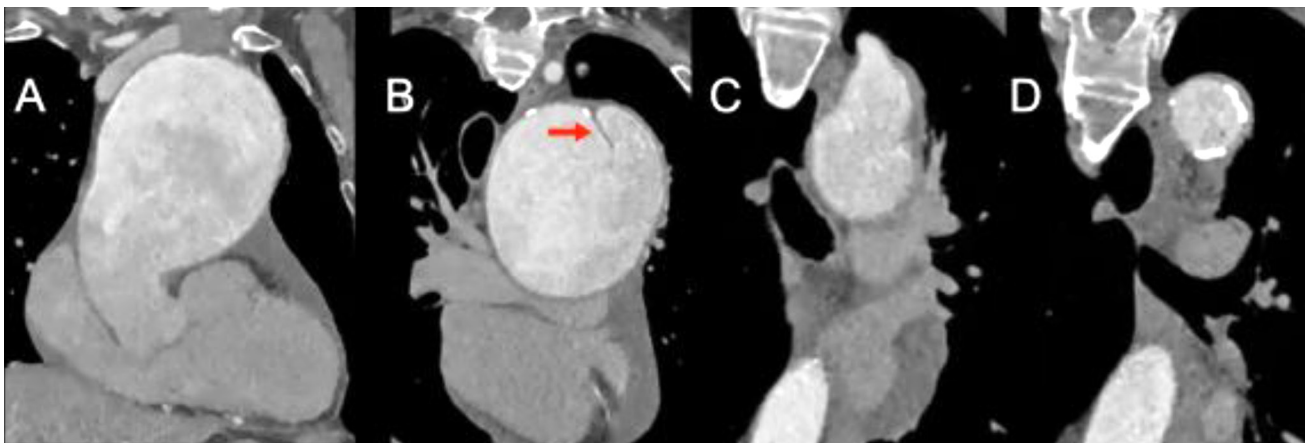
Computed tomography showing the ascending aneurysm (A) starting from the sinotubular junction, extending to the proximal descending aorta (B-D), with a localized dissection near the subclavian artery origin (arrow).
